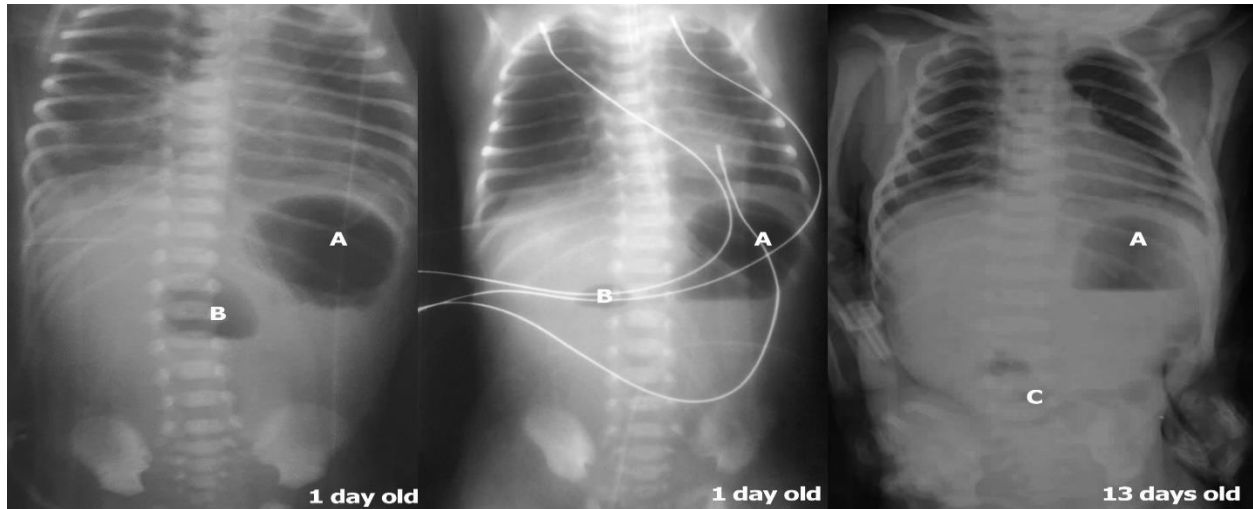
Plain radiography of the chest and abdomen in a direct projection in the vertical position: different types of gas in the the duodenum (A - stomach, B - duodenum, C - intestine).
